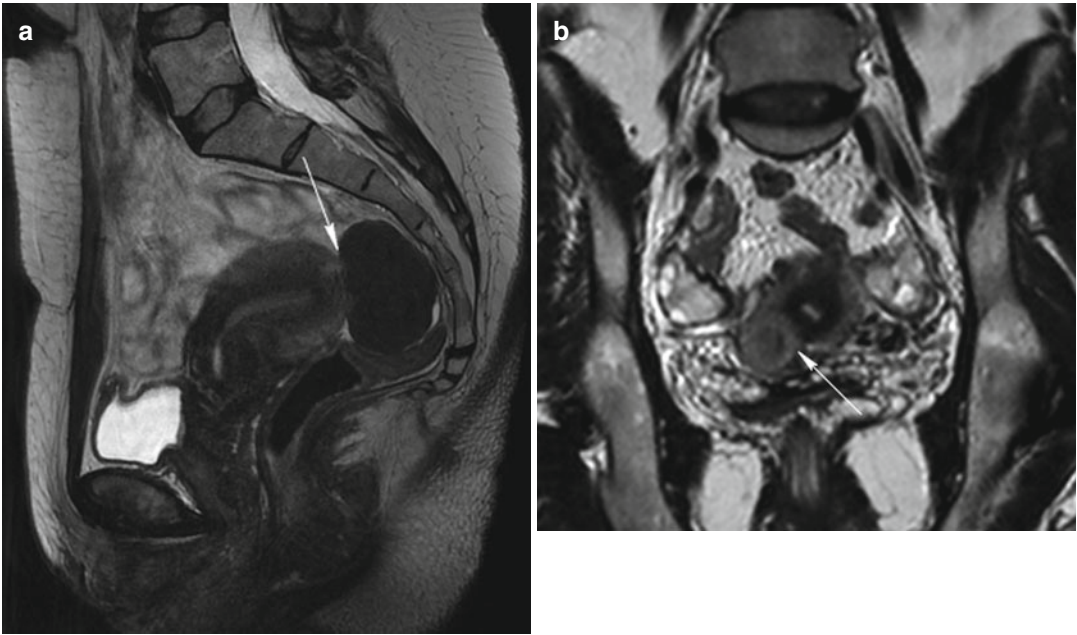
Pedunculated subserosal fibroids. Sagittal T2-weighted image (TR 4,700 ms, TE 90 ms) (a) shows a homogeneous hypointense well-defined mass at the fundus of the uterus that is a pedunculated subserosal fibroid with a little stalk (*arrow*). Coronal T2-weighted image (TR 3,700 ms, TE 100 ms) (b) of another woman shows a isointense well-defined mass within a hypointense area at
